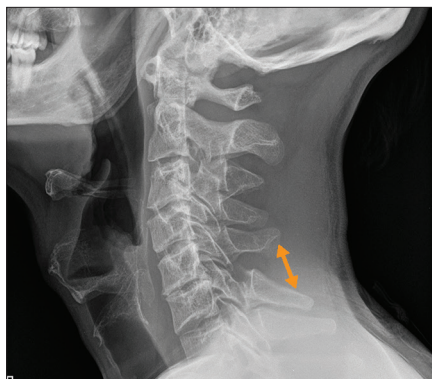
Lateral radiograph demonstrating C5-6 interspinous fanning (arrow), suggesting posterior longitudinal ligamentous disruption with probable fracture.
